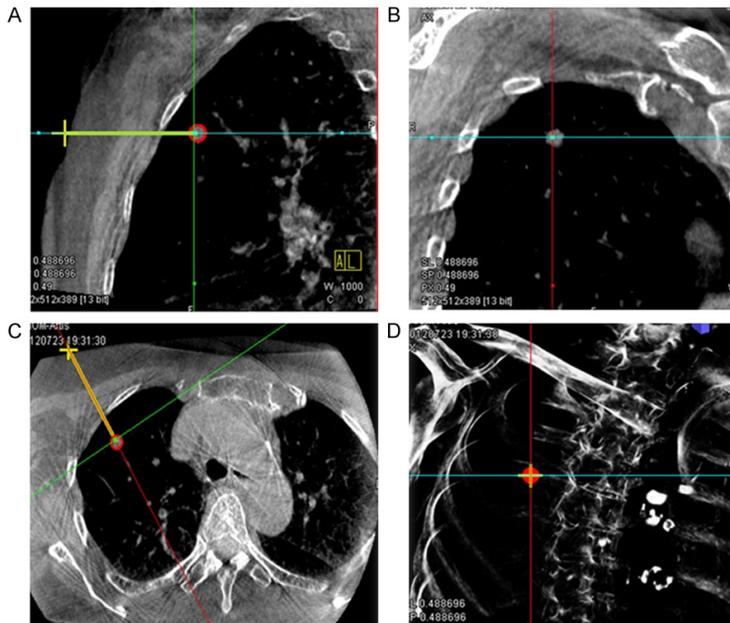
CBCT orthogonal multiplanar images with graphics showing planned needle path (yellow line) into target lesion (red circle) (A-C). The cross indicated the skin entry site and the circle indicated the target lesion site. The needle position relative to the anatomical structures was displayed in 3D using volume rendering technique (D).
